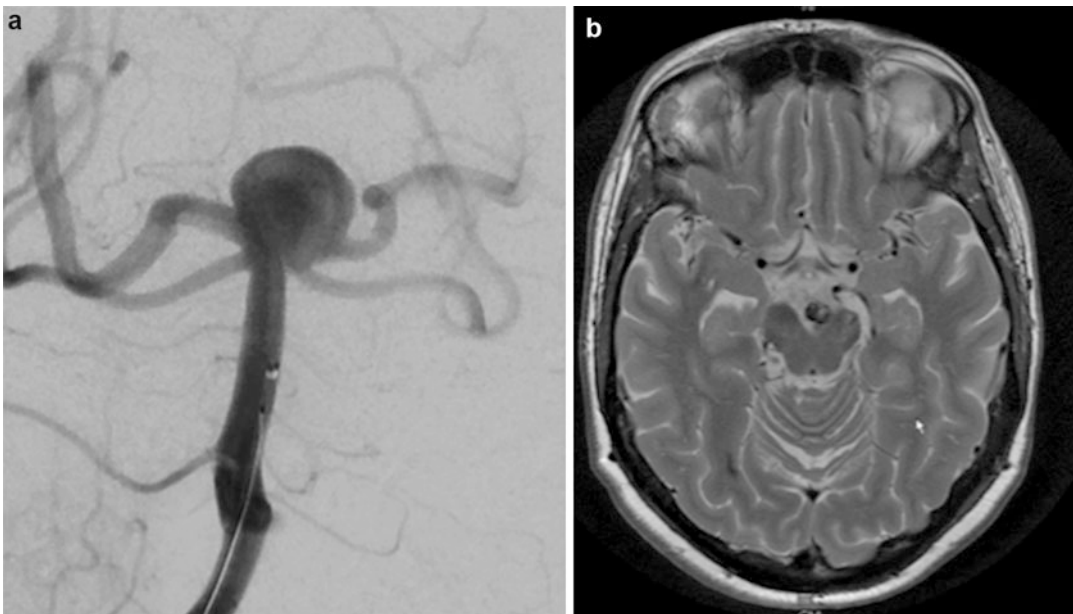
Pretreatment angiography of a wide-necked basilar artery bifurcation aneurysm with a maximum diameter of 8 mm (a) posterior-anterior (PA) view). MRI did not show
